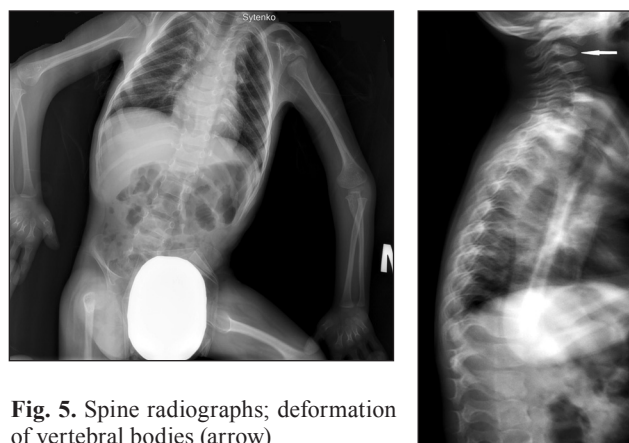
Spine radiographs; deformation of vertebral bodies (arrow)
